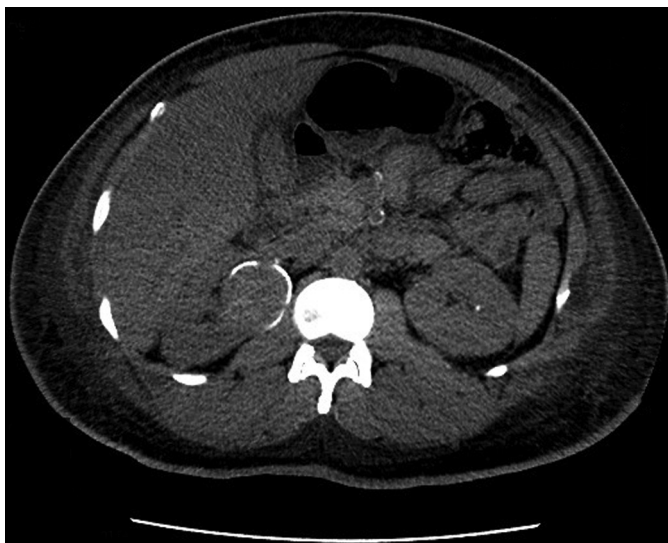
Abdominal/pelvic computed tomography (CT) image showing the renal mass before microwave ablation.
